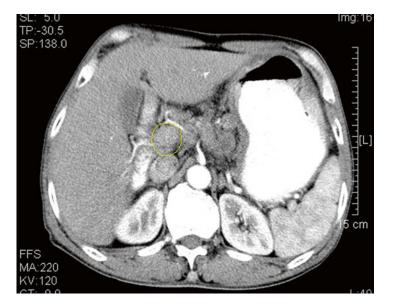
The preoperative CT image of No. 12 LNM (the *circle* represents the swollen No. 12 LNs)
